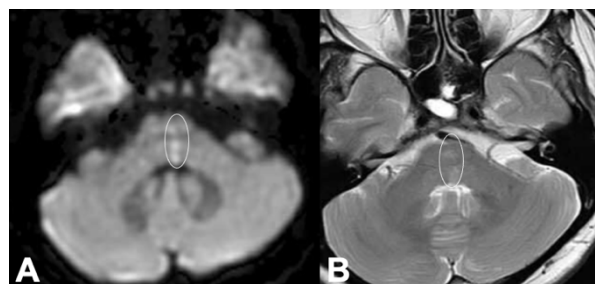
MRI demonstrates hyperintense signals (encircled) in the left dorsal paramedian pontine tegmentum at the level of the brachium pontis, seen on (A) DWI and (B) non-contrast T2-weighted imaging.
